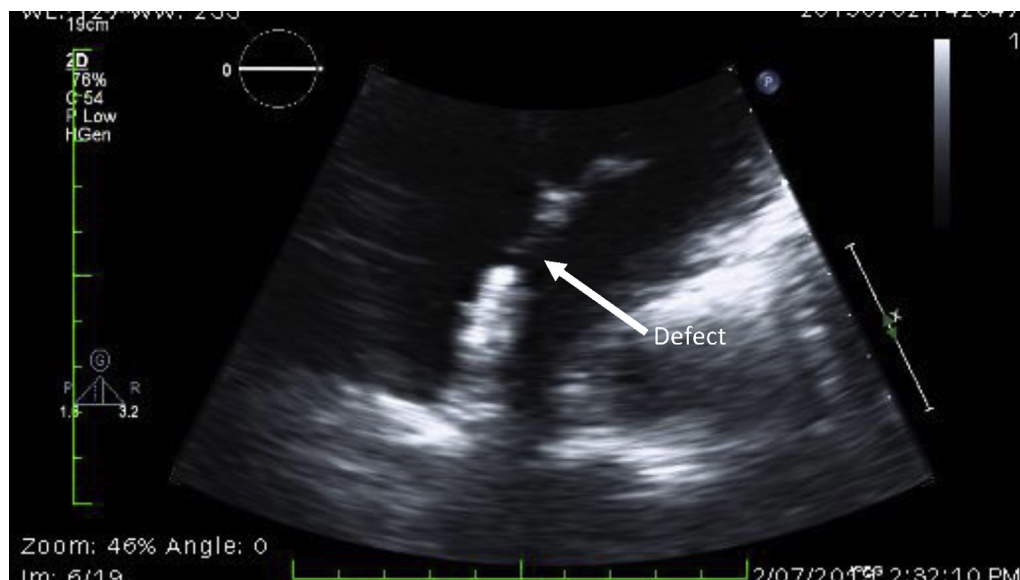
Transthoracic echocardiography highlighting patent foramen ovale (PFO).
